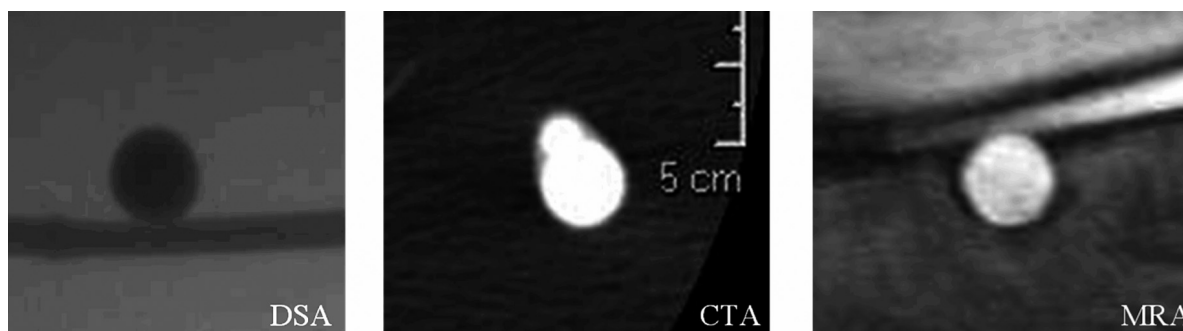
DSA, CTA and MRA images of one of the seven models.
